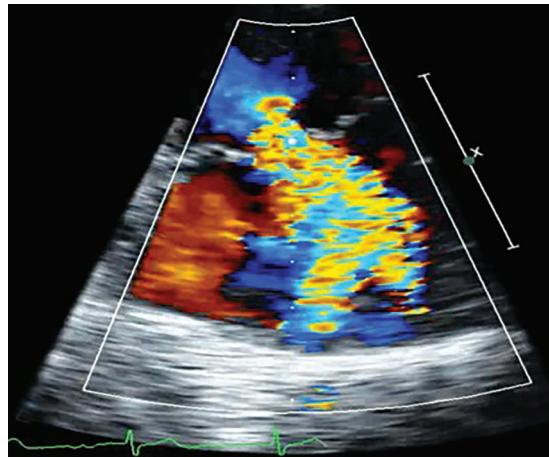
Preprocedural transthoracic echocardiogram demonstrates severe mitral regurgitation.
